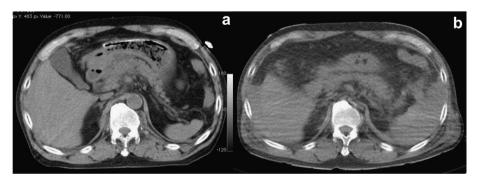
Comparison of the CT images at different postmortem time. (a) Shows the abdominal CT imaging taken immediately after death. The left renal calculus. Consolidation of the pancreas head. Calcification of the abdominal aorta. Right intra-abdominal hemorrhage. (b) Shows the CT imaging 54 h after death. The left renal calculus. Decreased consolidation of the pancreas head. Calcification of the abdominal aorta. Right and left intra-abdominal hemorrhage. Collapse of the abdominal aorta. The extent of intra-abdominal bleeding observed through CT images 54 h later was greatly increased.
